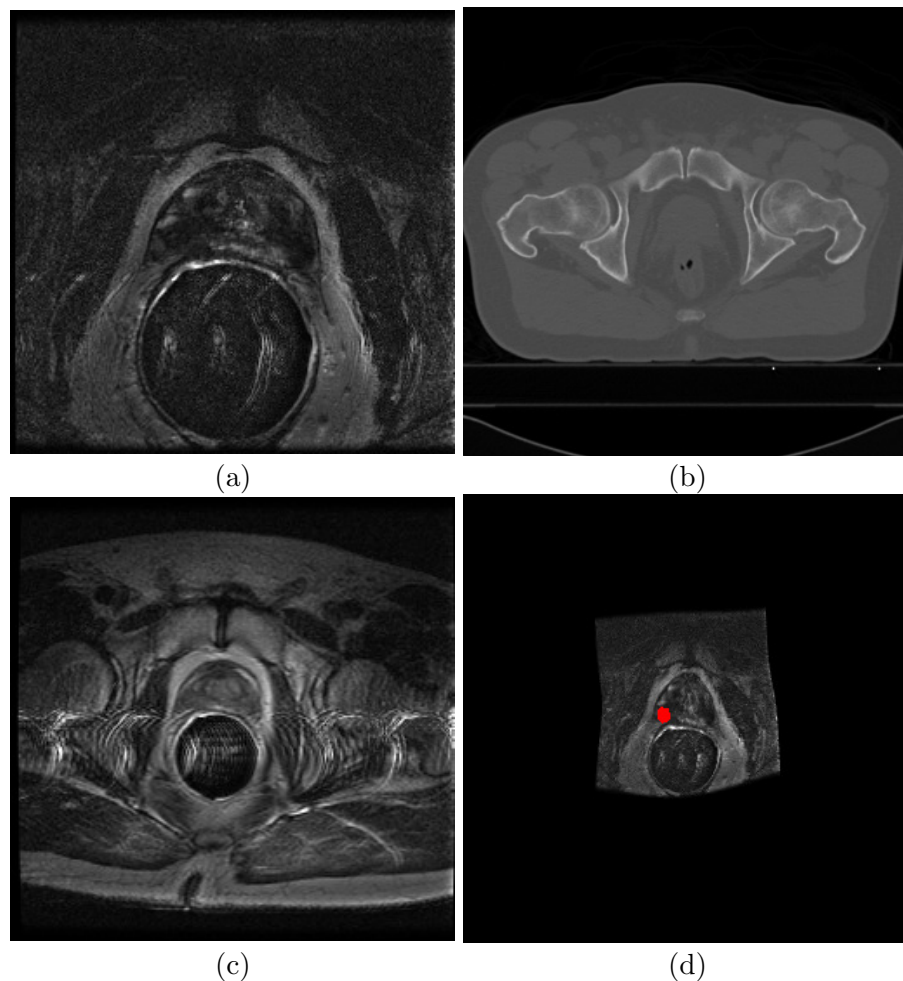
(a) Diagnostic MRI which may allow for identification of CaP extent. The diagnostic MRI must be registered to (b) planning CT so that a targeted dose plan may be generated. (c) Planning MRI can be used as an intermediary to facilitate alignment between (a) diagnostic MRI and (b) planning CT. (d) Registered diagnostic MRI (estimated cancer label in red) in alignment with planning CT.
